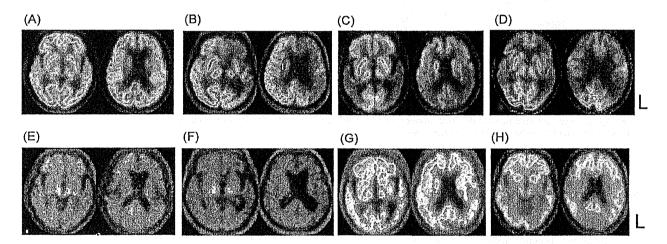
FDG-PET and <sup>11</sup>C PiB-PET. (A) In naPPA patients, FDG-PET analysis showed glucose hypometabolism in the left posterior fronto-insular region. (B) <sup>11</sup>C PiB-PET showed no abnormal signal lesion in the brain of naPPA patients. (C) In svPPA patients, FDG-PET showed glucose hypometabolism in the left anterior temporal lobe, while no PiB positive signal finding in cerebral cortices (D). (E) While lvPPA patients showed glucose hypometabolism in the left anterior temporal lobe by FDG-PET, <sup>11</sup>C PiB-PET showed abnormal high PiB signal findings in cerebral cortices of frontal lobes and temporal lobes and the posterior cingulate (F). (G) An early-onset AD patient showed glucose hypometabolism in bilateral frontal and temporal lobes, presenting abnormal PiB positive signal findings in cerebral cortices and the posterior cingulate in <sup>11</sup>C PiB-PET (H).
